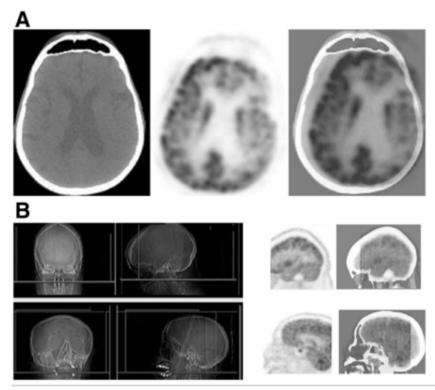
(A) 18F-FDG PET/CT images of the brain showcasing an excessive patient motion artifact. This artifact causes a false reduction in uptake in the left hemicortex. (B) Images show lateral x-ray scan and PET/CT images of the head. The views are transaxial and sagittal. This artifact is caused by a misplaced region-of-interest box on the scout images. This results in part of the brain being cut off in the final images. This is a technologist caused artifact (12).
